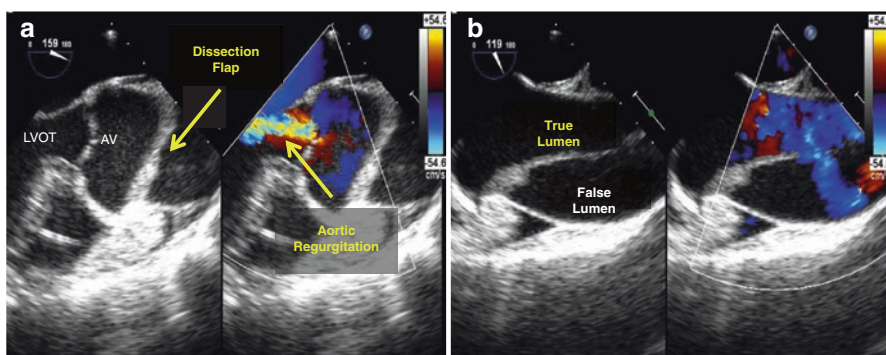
Type A aortic dissection on TEE. Panel (a): Dissection flap with color Doppler imaging of aortic regurgitation jet. Panel (b): True and false lumens of aorta in setting of aortic dissection and color Doppler imaging showing flow from true to false lumen. In this condition, a murmur of severe acute aortic regurgitation may be heard. *Abbreviations:* AV aortic valve, LVOT left ventricular outflow tract
